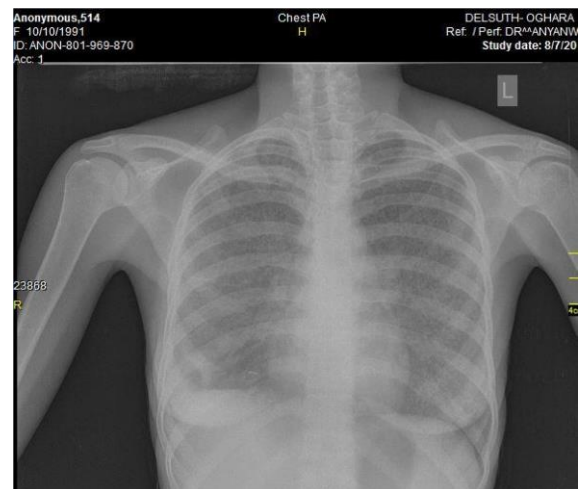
Posteroanterior chest radiograph of a 29-year-old female HIV sero-positive PTB patient showing widespread bilateral same-sized pin-head opacities suggestive of miliary pattern of PTB.
